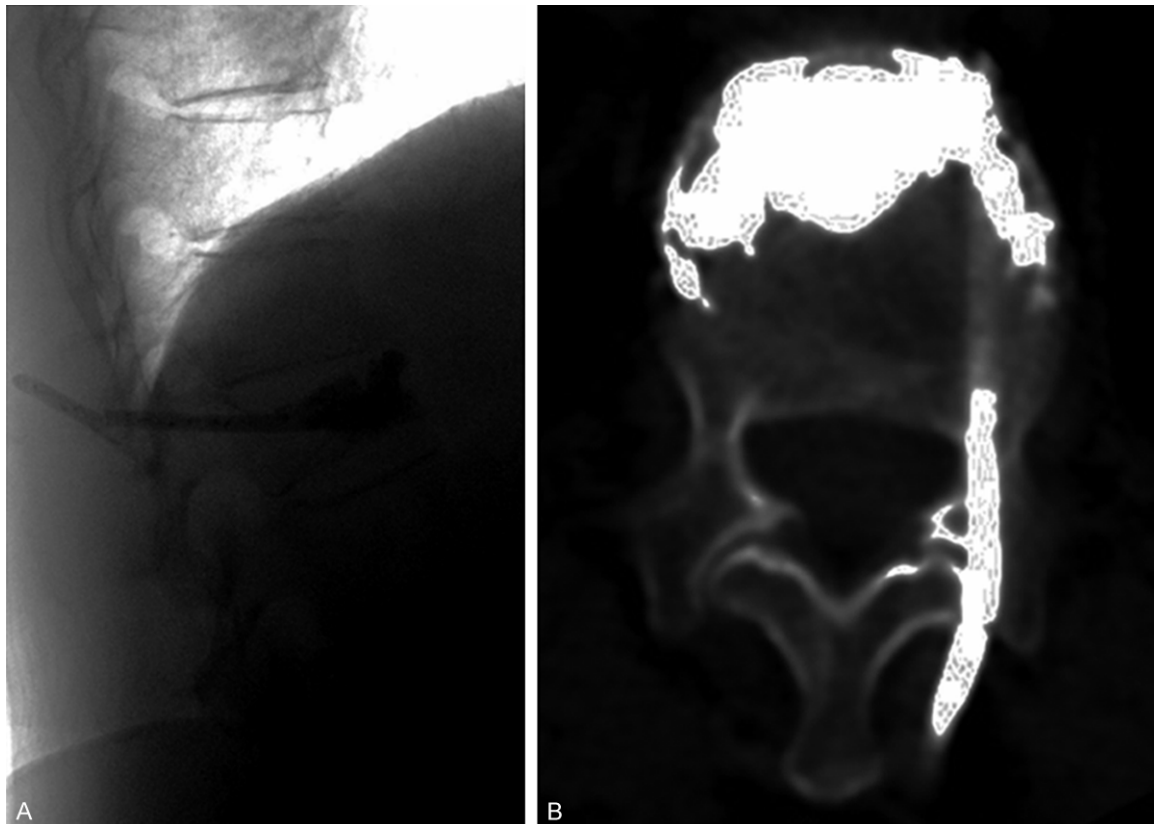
Imaging pictures of a 71 years old female OVCFs patient who had taken PKP treatment at L1. Bone cement residue was found in the paraspinal muscle intra-operatively and broke 7 years after operation, causing pain in the waist. The symptoms alleviated after removal of the residue. A. Radiograph lateral scan. B. CT base line scan.
